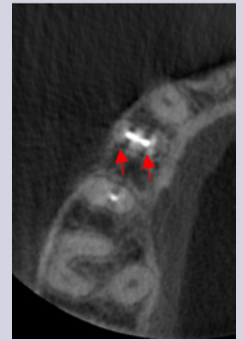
Axial CBCT image of teeth #3-6. Beam hardening artifacts (dark lines) can be seen going mesiodistally from the root filling materials on teeth #4 and 5. These are NOT root fractures.
